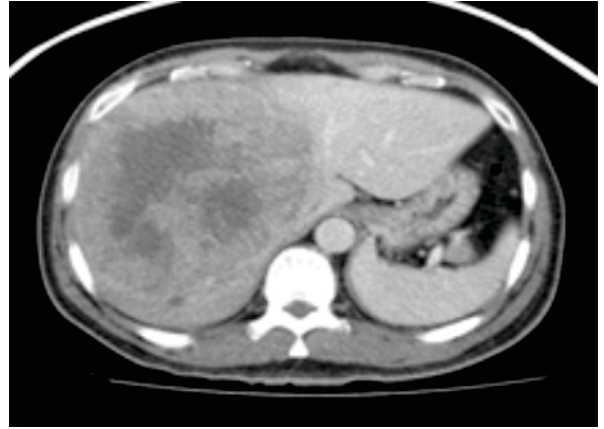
CT Showing HCC In Portal Phase
